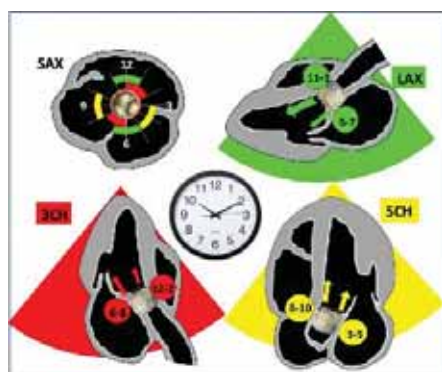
The methodology of paravalvular leak assessment in standard transthoracic echocardiographic examination projections after transcatheter aortic valve implantation procedure
